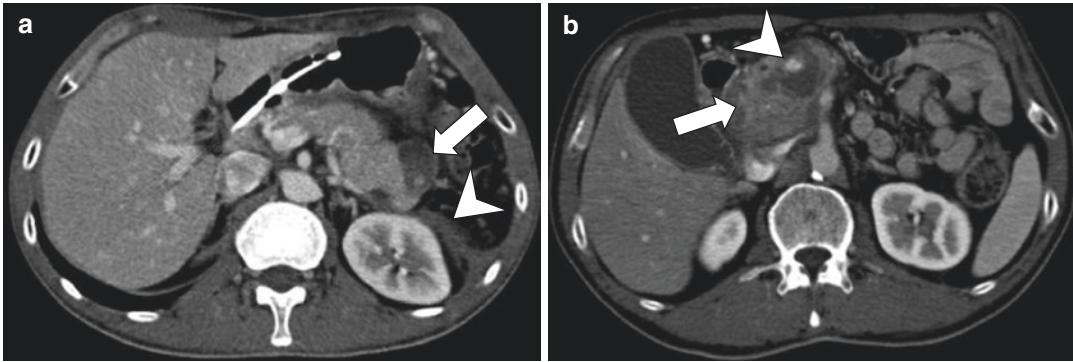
Other findings of chronic pancreatitis on CT. CECT axial (a) image shows the pancreatic pseudocyst (arrow) and the peripancreatic fascia thickening (arrow head) in the tail of the pancreas. CECT axial (b) image
